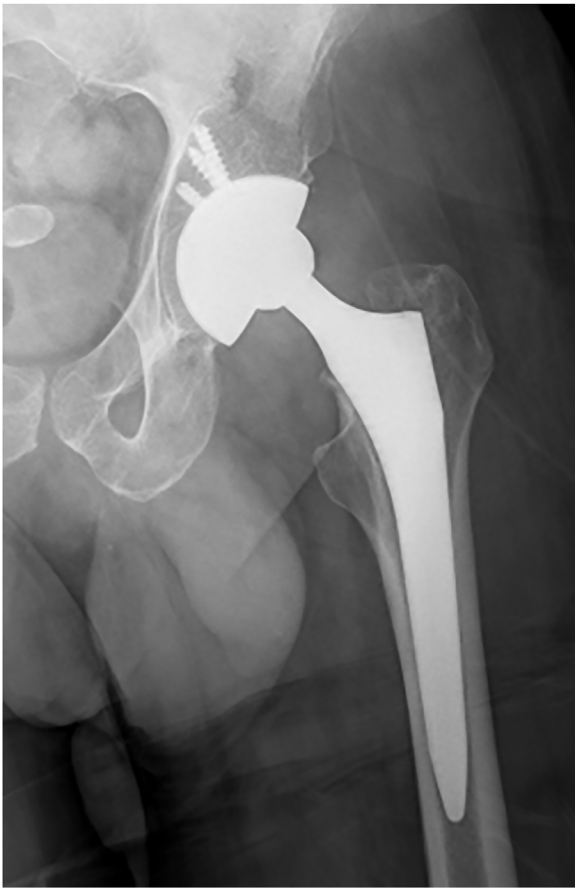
X-ray images demonstrating a fatigue fracture. It was presumably caused by chronic infection and fracture non-union.
